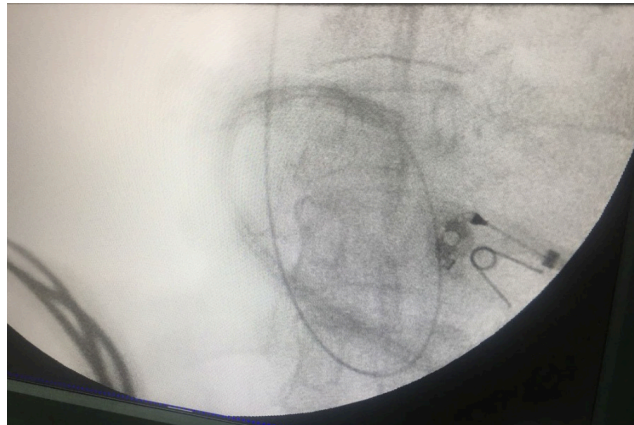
Fragmented TDC showed in Mobile C-arm X-ray
